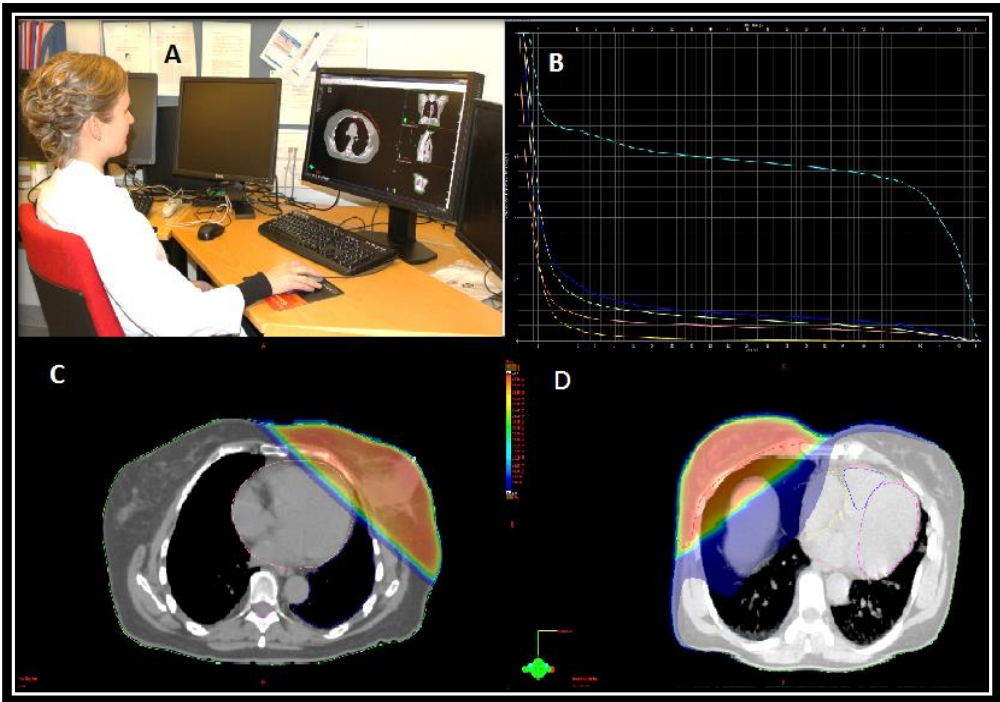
Radiotherapy planning. On the left upper corner (A), radiation oncologist is contouring treatment doses on her workstation. The right upper corner (B) shows dose-volume histograms for different cardiac structures derived from 3D treatment planning. The bottom figures show 3D CT treatment planning in one plane for a patient with left-sided (C) and for a patient with right-sided (D) breast cancer. The different colors in the CT images indicate different radiation doses, blue coloring indicating lower doses and increasing doses from yellow to red. The treatment doses are shown with 5 Gy for red color in patients with left-sided breast cancer (C) and 1 Gy in patients with right-sided breast cancer (D).
